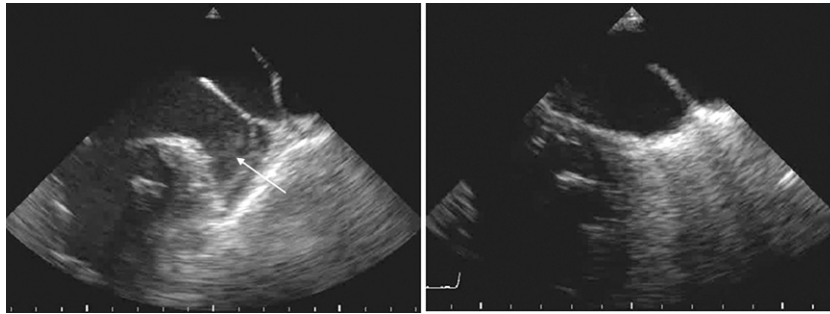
Intraoperative Transesophageal Echocardiograms Before and After Appendectomy
